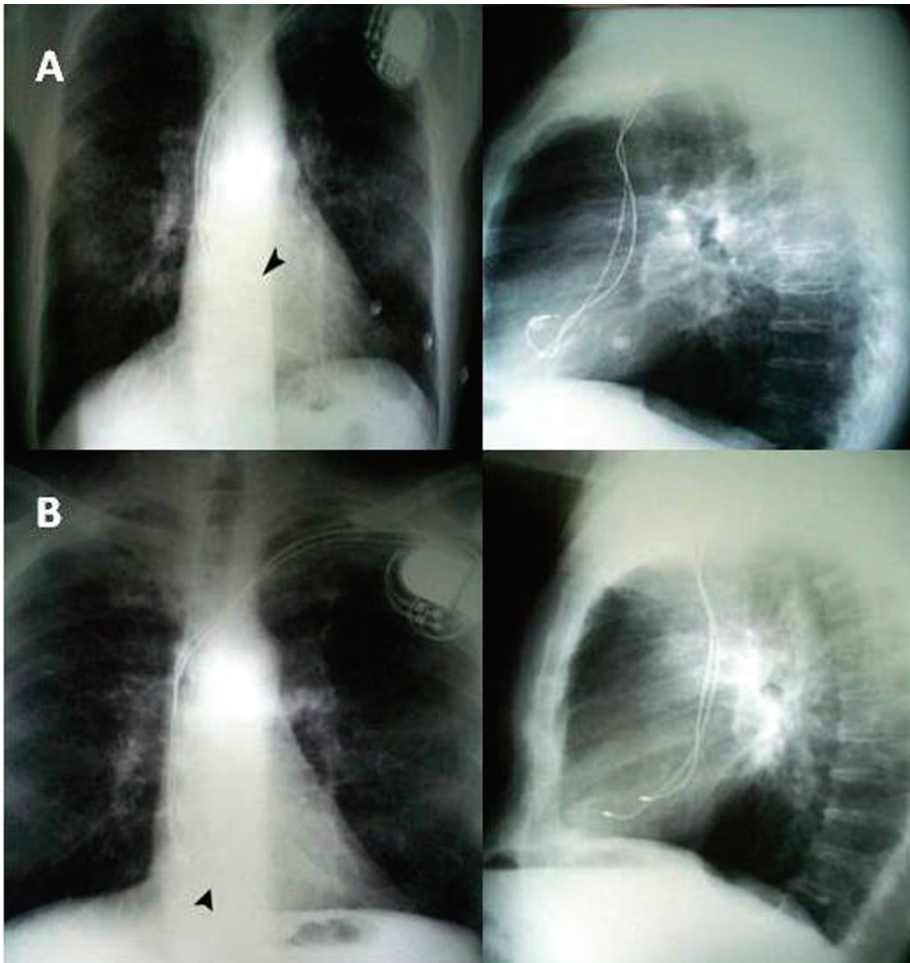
Top (A): Postero-anterior and lateral chest X-ray films obtained 24 hours after pacemaker implantation showing atrial lead tip (arrow head) inside the right atrial appendage; Bottom (B): Radiograph obtained three months later showing displacement of atrial lead (arrow head) towards tricuspid annulus.
